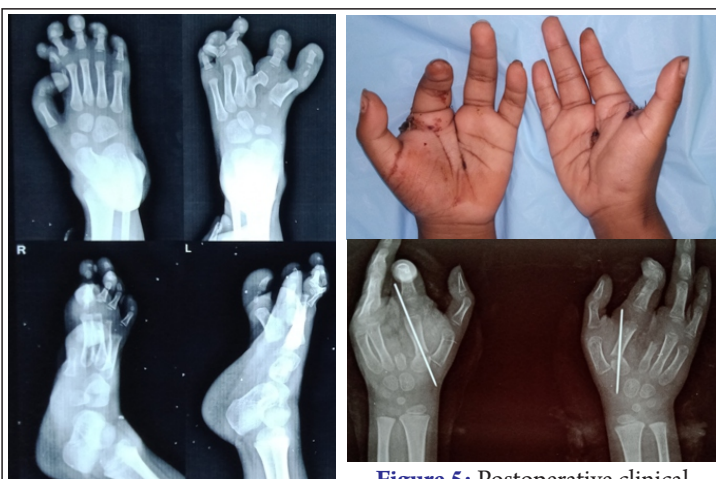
Anteroposterior and lateral radiographs of both feet
